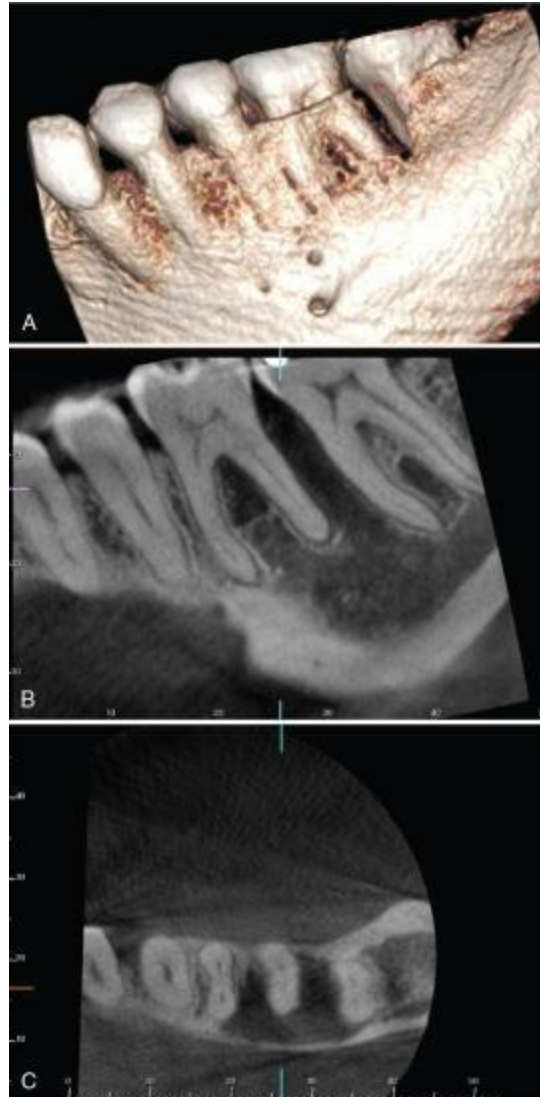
A, Volumetric rendering reveals multiple osseous defects throughout the mandible consistent with multiple myeloma. B, Sagittal CBCT image showing a well-defined and destructive low-density lesion. C, Axial CBCT image exhibiting destruction of the trabecular bone and marked thinning of both buccal and lingual cortical plates.
